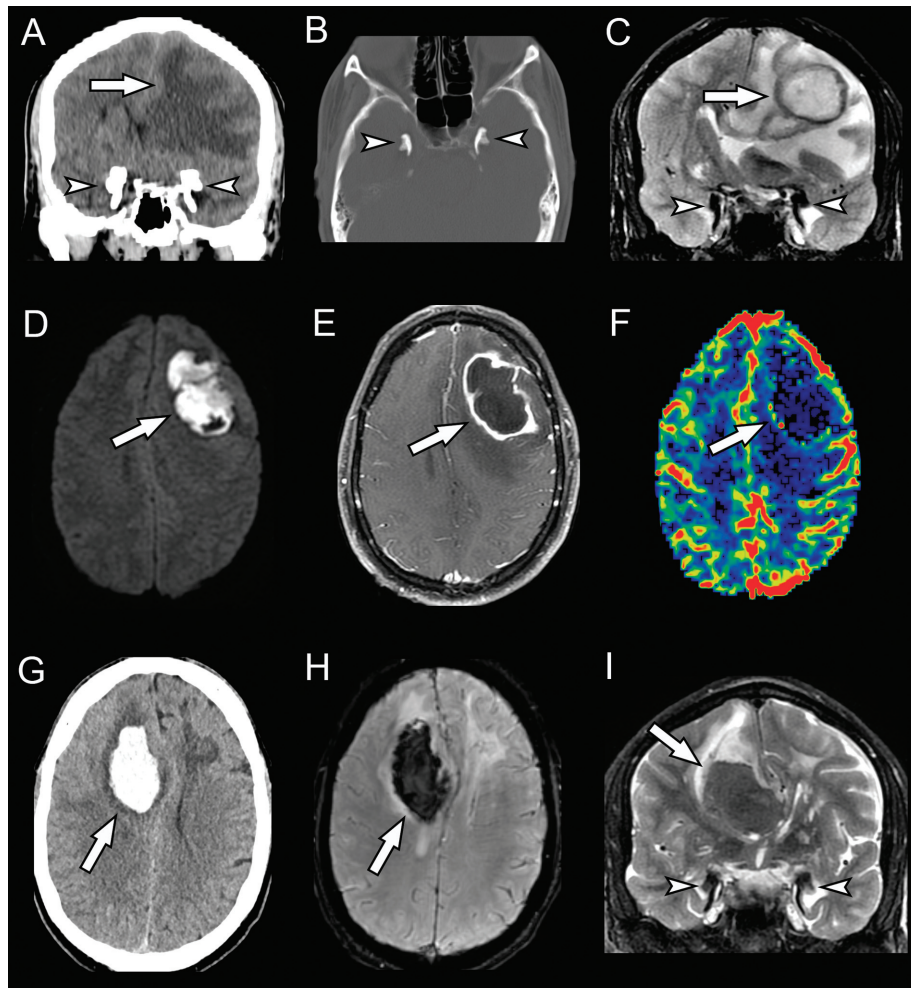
A noncontrast CT scan (A) demonstrates amygdalae comma-shaped calcifications (arrowheads) and hypoattenuation in left frontal lobe (arrow). A CT scan of the bone window (B) also shows calcifications (arrowheads). The coronal T2WI (C) depicts hypointense calcifications (arrowheads) and a lesion in left frontal lobe (arrow). Both DWI (D) and postcontrast T1WI (E) show central restricted diffusion and peripheral enhancement; no significant change in CBV color maps (F) is noted (arrows), suggesting an abscess. After 4 years the patient returned with an intraparenchymal hemorrhage in the right frontal lobe, seen in the noncontrast CT scan (G), SWI (H), and coronal T2WI (I) (arrows). Again, there are signs of calcification (arrowheads in I).
